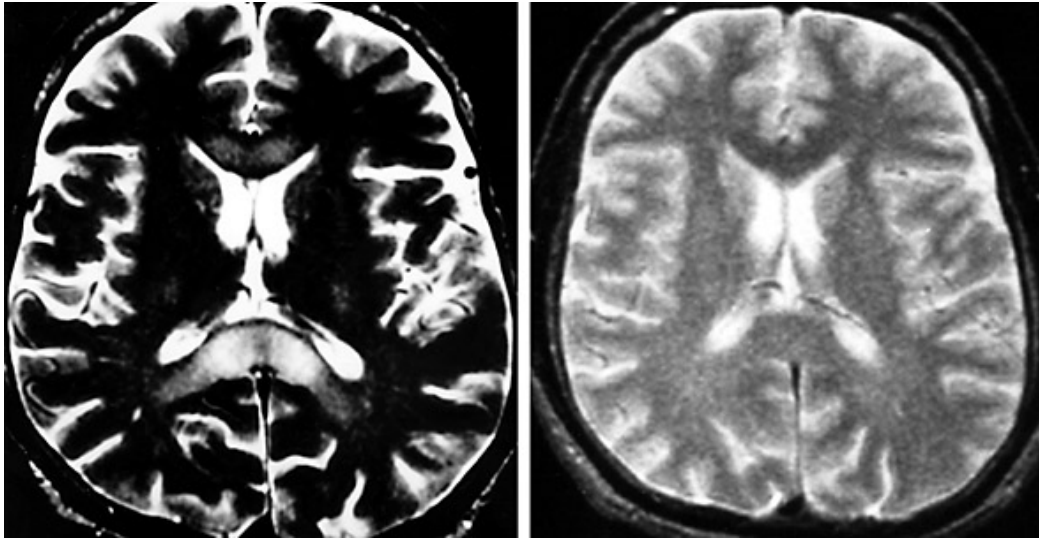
MRI scans of a patient suffering from high-altitude cerebral oedema: Left, Axial T2-weighted magnetic resonance image of patient 9 demonstrating high signal in splenium and mild increased signal in centrum semiovale. Right, Axial T2-weighted magnetic resonance image of the same patient demonstrating complete resolution of abnormal signals 11 months later (Hackett et al., 1998).
